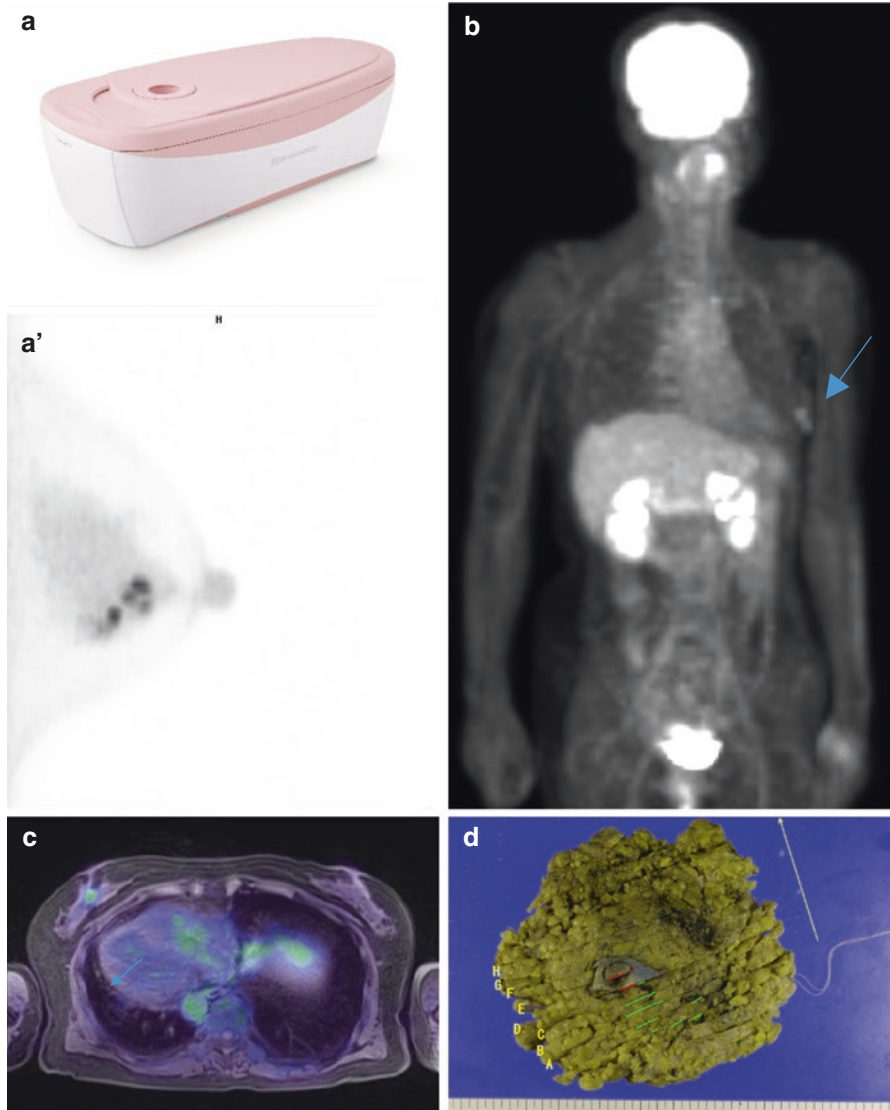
Comparison between FDG uptake of each FDG PET, PET/MRI, and dbPET. 60-year-old woman with Lt. invasive ductal carcinoma. (a, a') dbPET (Elmammo[®]) and imaging: Multiple FDG hot spots in lower bottom area from nipple to peripheral site (SUVmax5.81). (b, c) Whole-body FDG PET and FDG PET/MRI: Lower FDG hot spot in Lt breast (SUVmax 1.8). (d) Pathological findings: invasive ductal carcinoma (Red: 1.5 cm invasive lesion, Green: 4.5 cm ductal carcinoma in situ) ER90%, PgR30%, HER2 1+, Ki67 20%. *Source:* Hashimoto R. et al. The usefulness and future aspect of Dedicated Breast Positron Emission Tomography in the clinical settings. *Shiniryō* 2016, 43(11), 33
